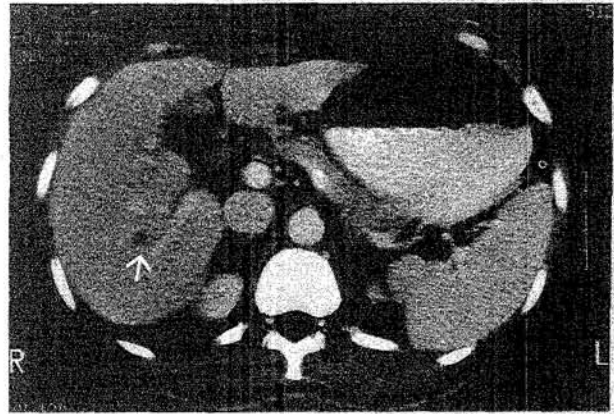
Reassessment CT scan of the same patient revealing significant response of the liver metastases to regional intra-arterial chemotherapy. His primary tumour (arrow) also disappeared completely after chemotherapy
